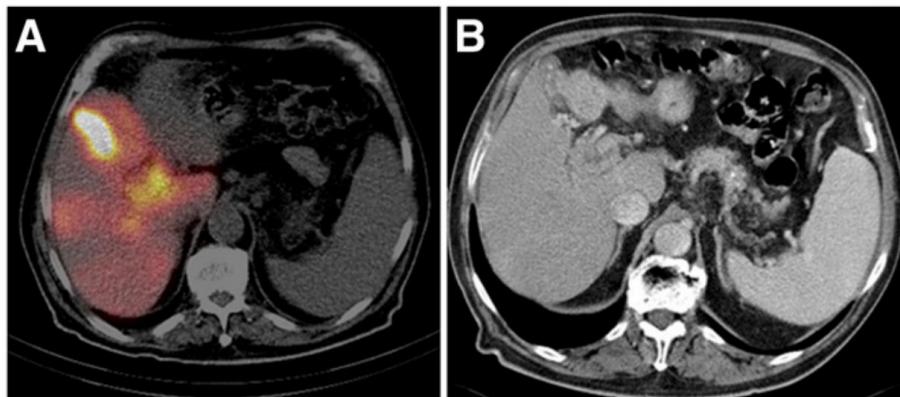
A: SPECT/CT with 99mTc-MAA; B: triple-phase diagnostic CT (53).
